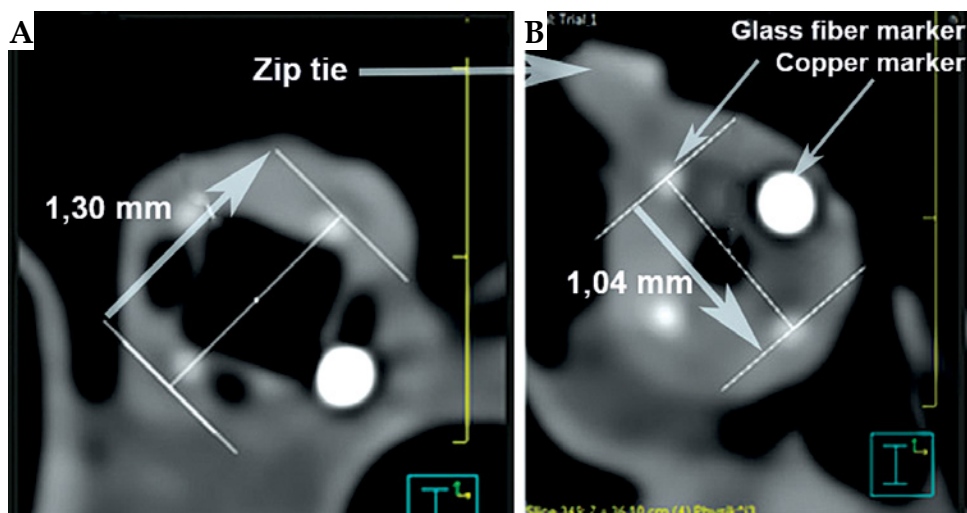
CT images. A) Applicator before neostenosis; B) Applicator in neostenosis
